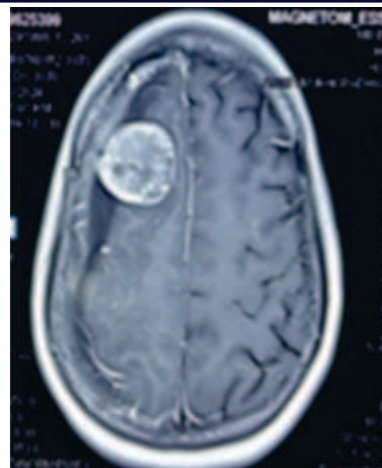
MRI T1+ Contrast Pre-op Image(Axial)
